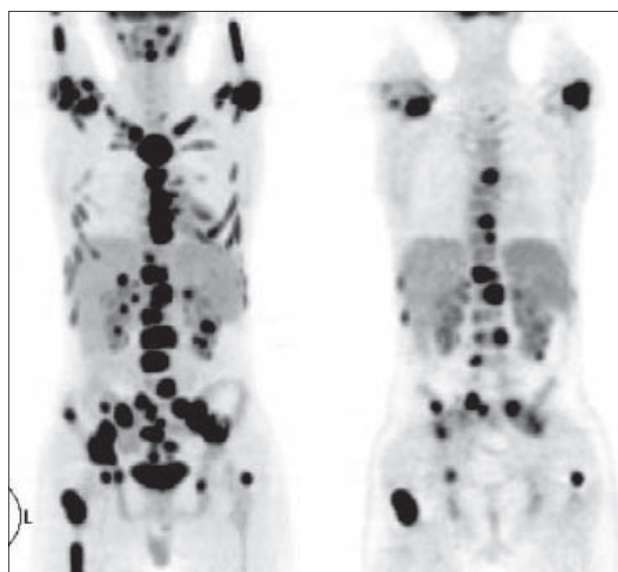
Ca. Initial (at diagnosis) <sup>18</sup>F-FDG-PET shows viable lesions in the sternum. The thoracic and lumbar vertebrae of cord, and bilateral scapulae, humers, femurs, pelvis bones.
